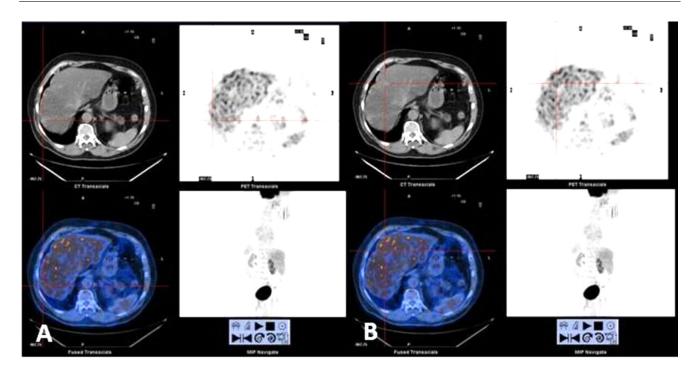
Fluorodeoxyglucose - positron emission tomography (PET) scan that did not reveal any uptake or signs of metastases in the site of lesions detected with US and CT (A lesion in segment VII), (B lesion in segment VIII).
